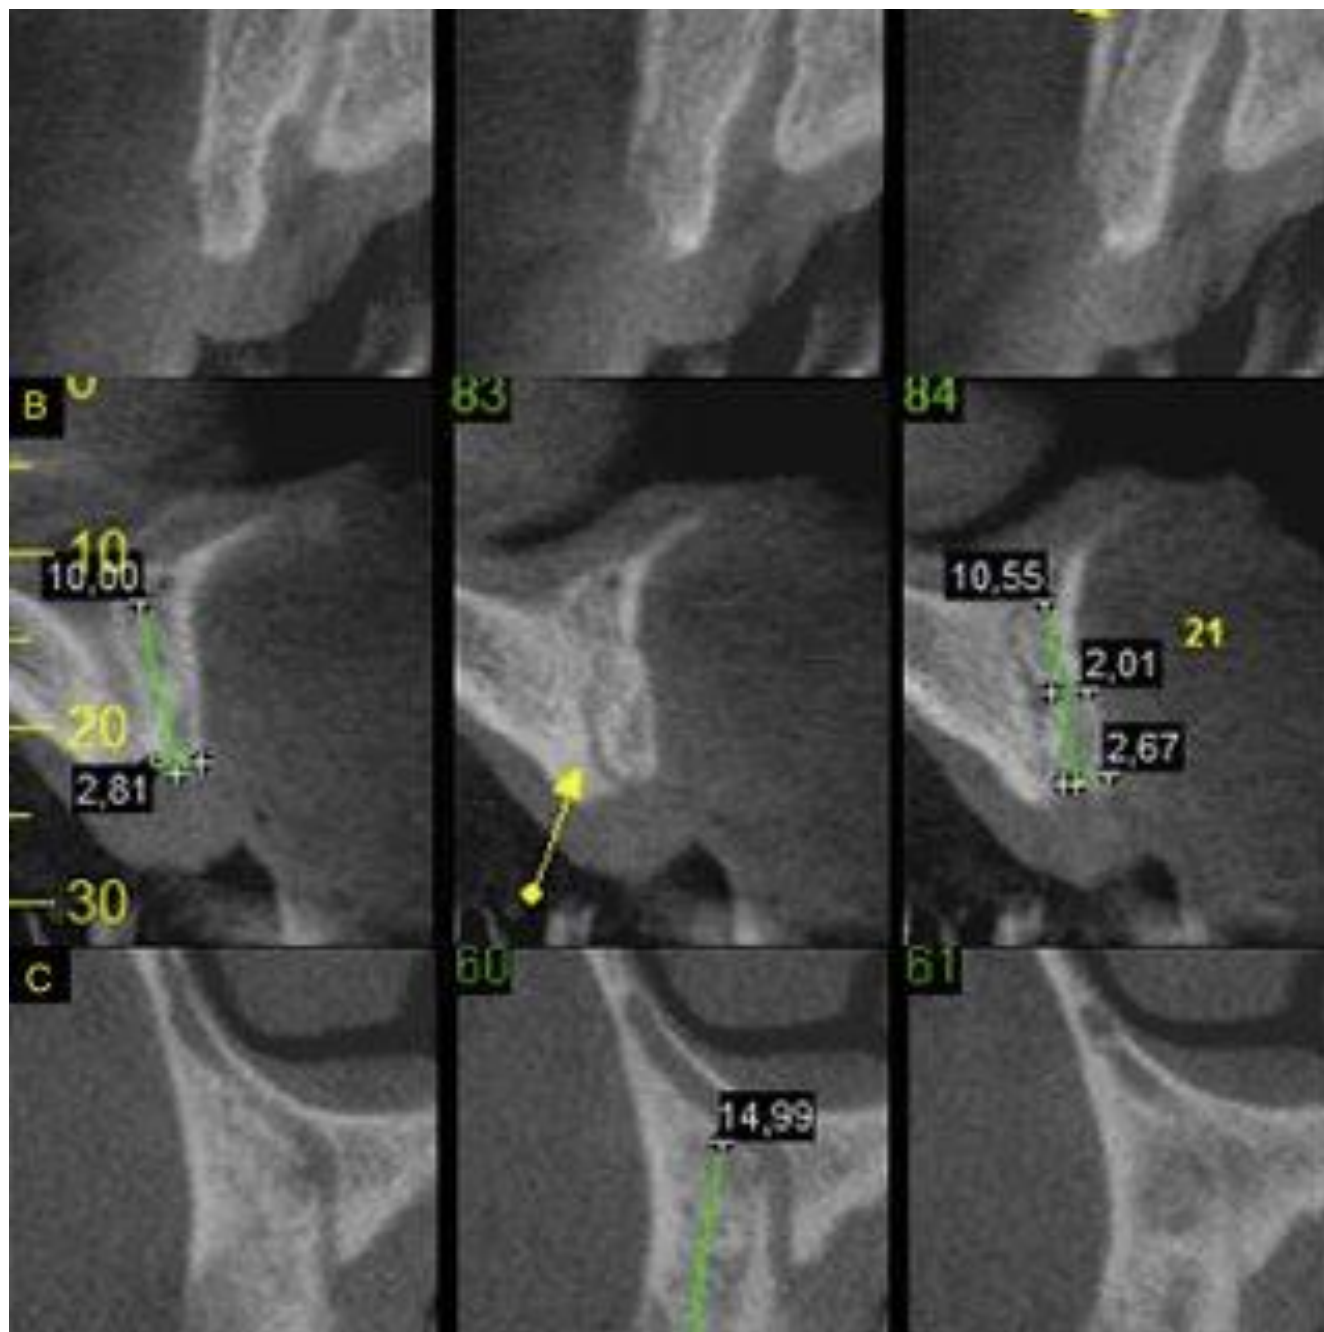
(A) Anterior superior alveolar nerve. (B) Canalia sinuosus is an anatomic variant leading to placement of implants into the canal leading to a soft tissue interface. Axial CBCT image showing location in center of residual ridge. (C) Cross-sectional CBCT image depicting the canalia sinuosus. (A, From Wells M: *Local and regional anaesthesia in the emergency department made easy*, Edinburgh, 2010, Churchill Livingstone.)
